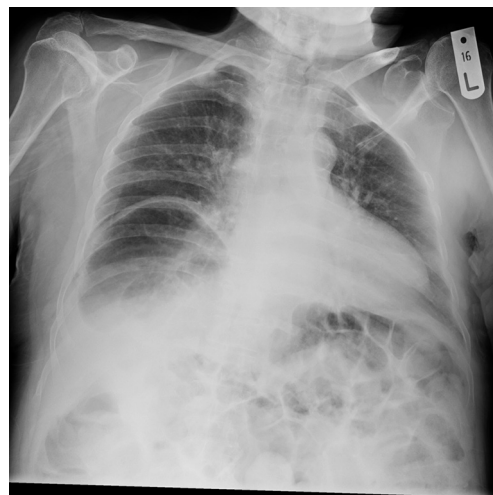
Chest X-ray showing improvement after manual evacuation.
